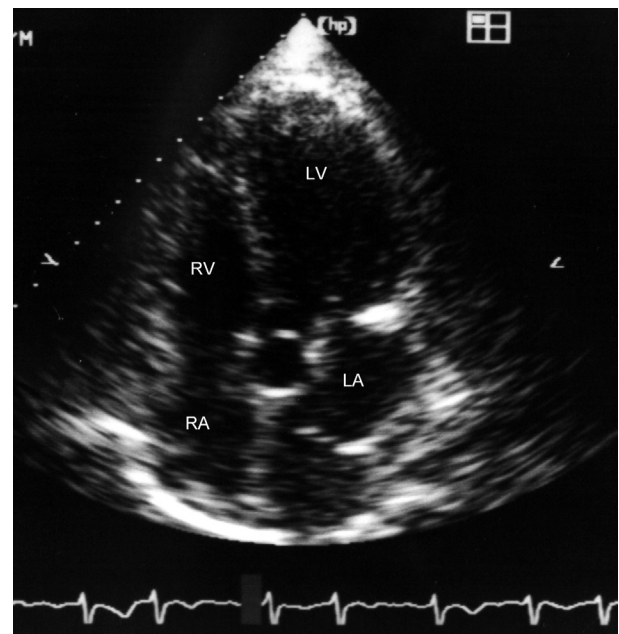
Transthoracic two-dimensional echocardiography shows the presence of a membrane that divides the left atrium into posterosuperior and anteroinferior chambers from the apical four chamber view.
